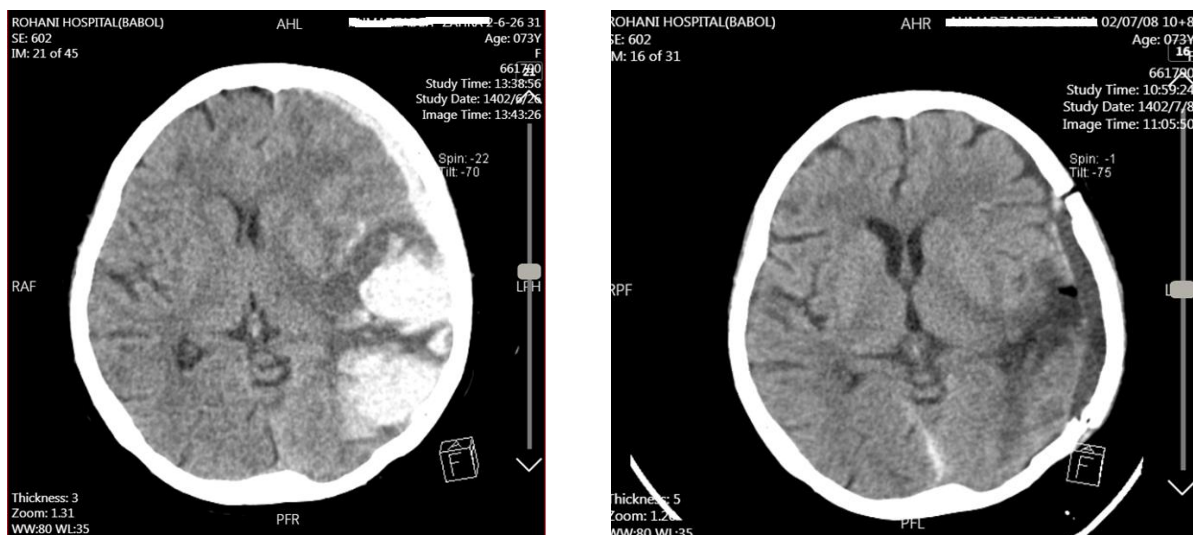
Left side of the brain CT scan and SDH shows left frontoparietal ICH and a 13mm mediolateral shift (MLS), and the right side shows day 10 after surgery.
